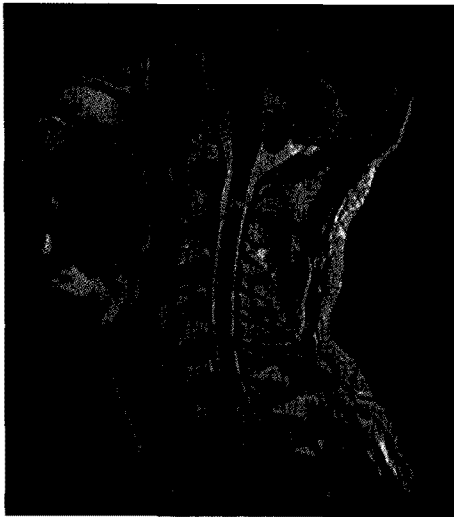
T2-weighted sagittal image of the cervical spine shows an intramedullary signal abnormality at the level of C2 suggestive of cord contusion.
